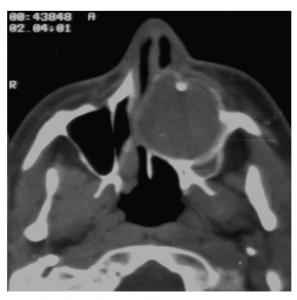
Axial CT of a maxillary mucocele.
